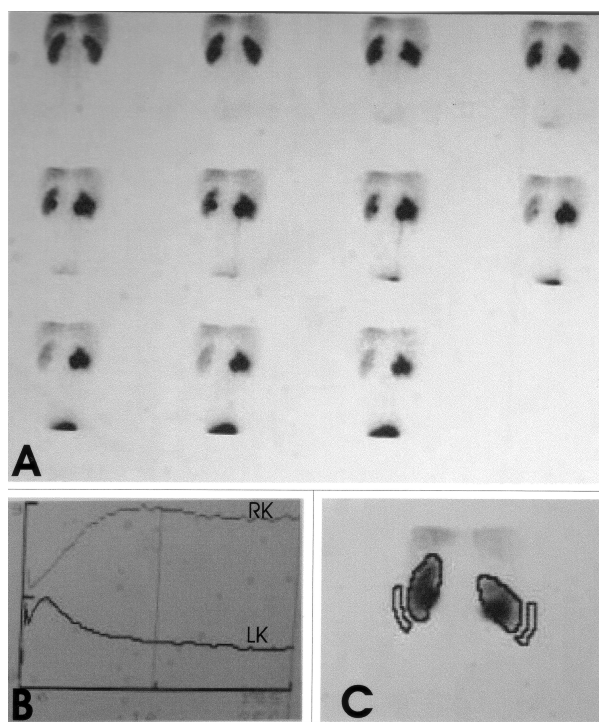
Preoperative renal scintigraphy images in a 32-year-old patient (A). Renogram shows obstructive pattern and no drainage after diuretic administration (B). Differential renal function was 61% in the left kidney and 39% in the right kidney. LK = left kidney, RK = right kidney.
